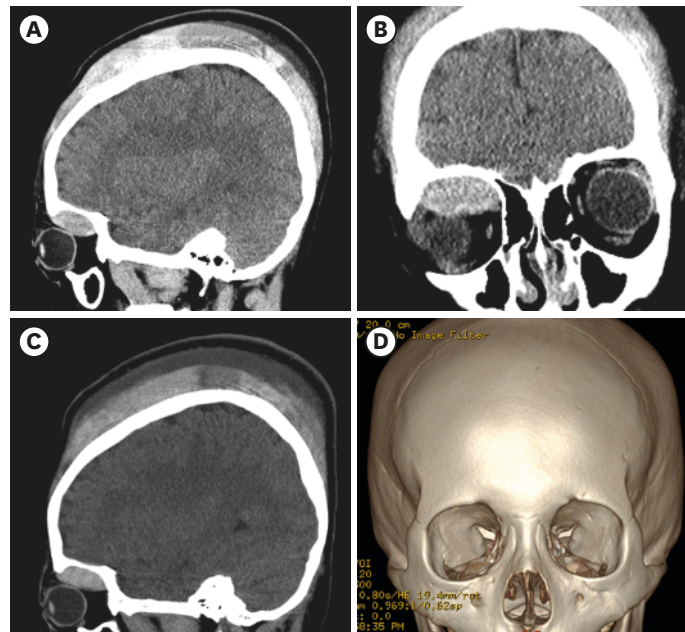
CT scans after the development of proptosis in the right eye. The CT scan was taken after an emergent needle aspiration on the forehead and a compressive bandage application. An IOH can be noted in the sagittal (A) and coronal (B) view. The hematoma was located in the superior medial aspect inside the right orbit and convex in shape. It happened in the subperiosteal space of the orbit. The relative less hematoma in the frontal area compared with the vertex may have resulted from hematoma aspiration and bandage compression (C). The IOH was not increased 3 days after the proptosis occurred. The 3-dimensional skull rendering image shows the larger supraorbital notch/foramen in the right orbit compared with the left (D).
